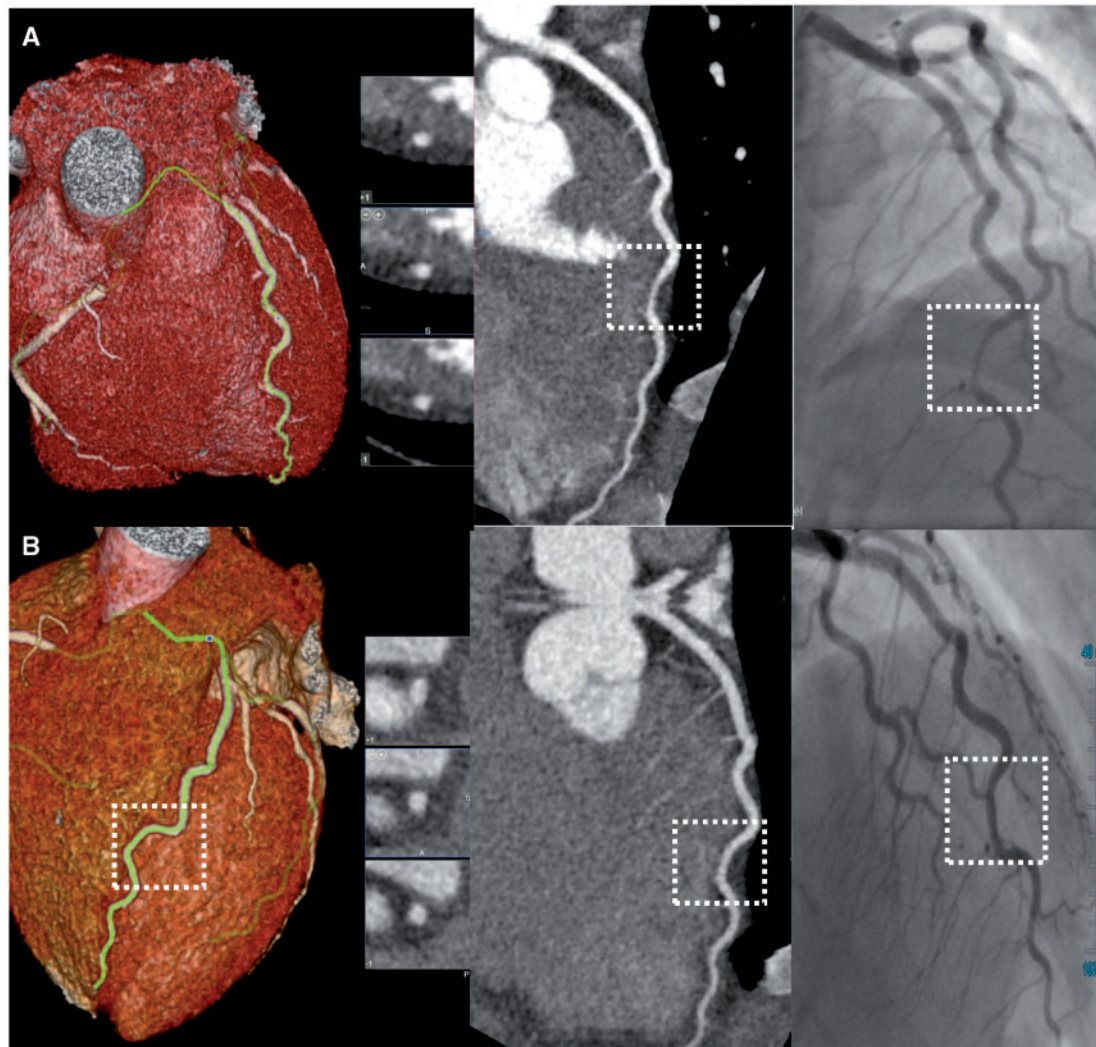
Coronary computed tomography findings with parallel angiographic images for a Type 2A dissection of the left anterior descending coronary artery at presentation (A) and following healing after 3-months follow-up (B).
